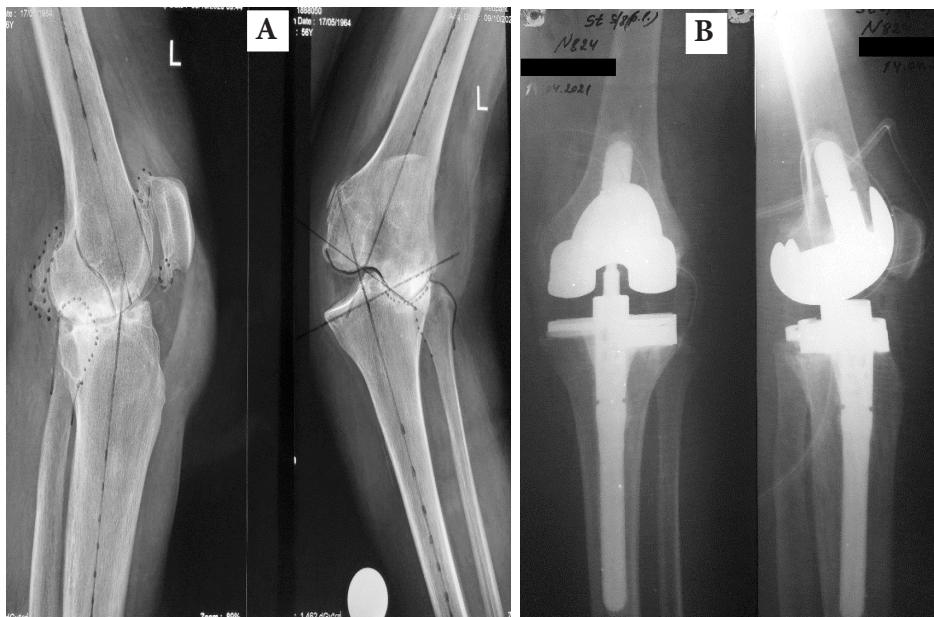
CKP with augmentation 10 mm on lateral plateau implanted in a 56-year-old woman with a valgus deformity of 30° of the left knee. A – Pre-operative radiographs, B – Radiographs after surgery
